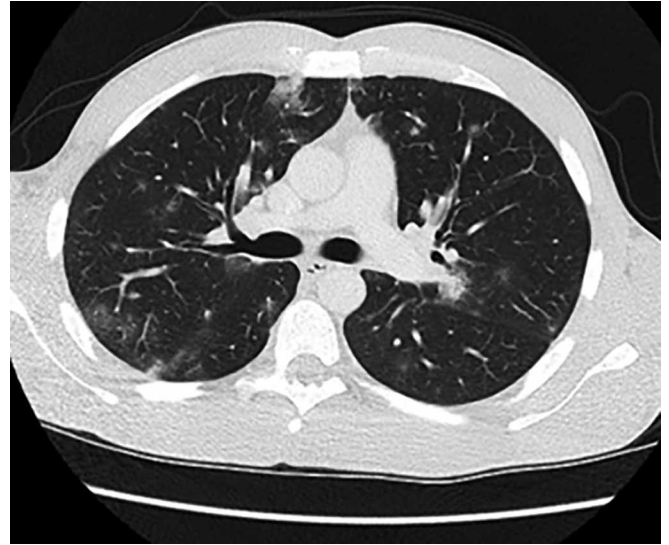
Typical computed tomography [CT] chest scan from a patient with common variable immunodeficiency disorder at the time of initial diagnosis with granulomatous-lymphocytic interstitial lung disease. The patient was asymptomatic but had impairment in gas transfer. The CT also demonstrated splenomegaly.
